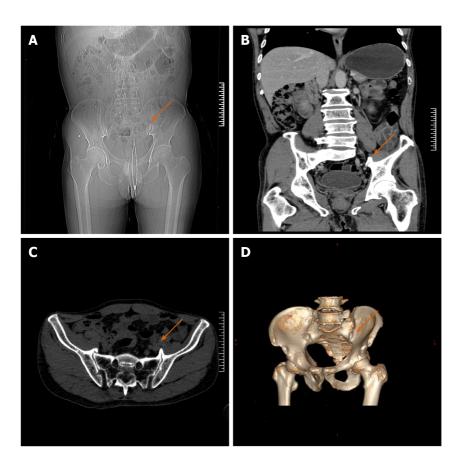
Pelvic computed tomography scan plus 3D reconstruction before the operation. A: Anteroposterior radiograph of the pelvis; B: Coronal computed tomography scan showing the osteophyte in the left sacroiliac joint, as indicated by the orange arrow; C: Horizontal scan showing that the left osteophyte was more prominent; D: 3D reconstruction revealing the osteophytes that were in the anterior lower part of both sacroiliac joints, with the left osteophyte being larger, as indicated by the orange arrow in the figure.
